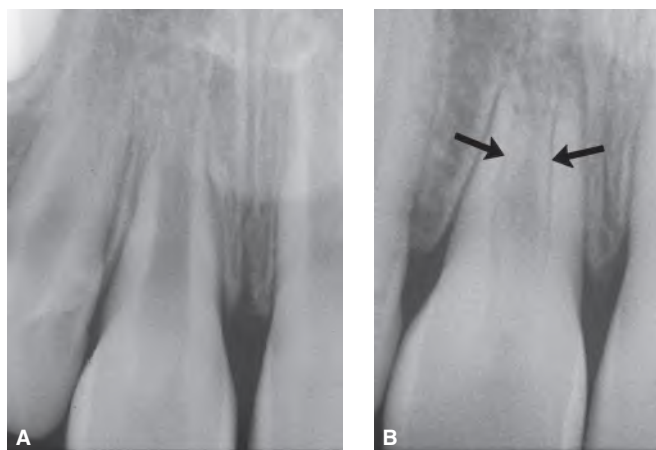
Revascularization of an immature root. A tooth with an open apex was replanted soon after the avulsion. A shows the radiographic picture immediately after replantation B. The follow up taken The follow-up radiograph 1 year later suggests that revascularization had taken place. In this case, it appears that new periodontal tissue has formed with a lamina dura and bone growth within the pulp canal (black arrows). (Courtesy of Dr. Cecilia Bourguignon, Paris, France.)
